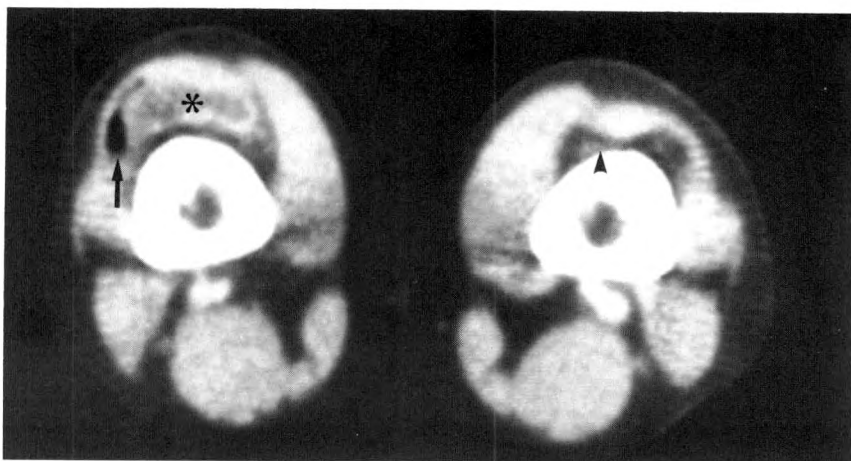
Noncommunicating antefemoral cyst. Postarthrography CT scan shows noncommunicating cystic lesion (*asterisk*) anteromedial to air-filled joint (*arrow*). Lesion shows semilunar shape with irregular, thick wall. Normal suprapatellar bursa is seen on patient's left side (*arrowhead*).
